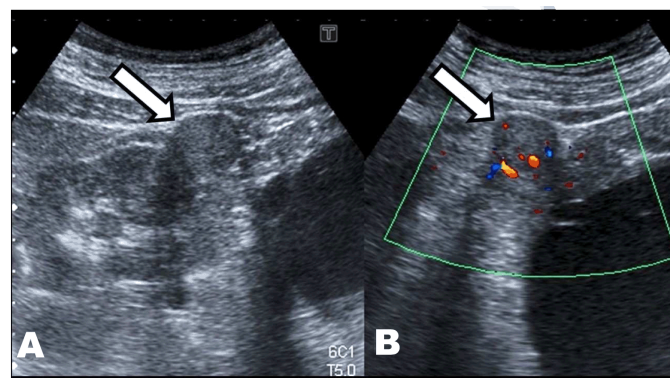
Ultrasound image of the upper pole of right kidney. (A) B-mode image with an echogenic nodule, with rounded morphology (white arrow), (B) Doppler mode reveals the presence of vascularization in this nodule (white arrow).
